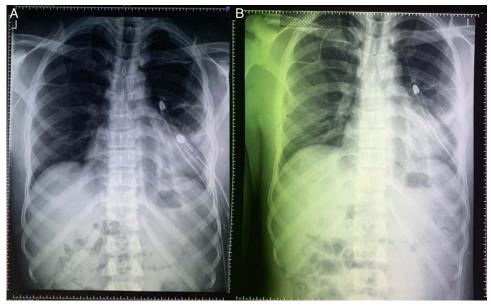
(A) shows chest radiography just after the surgery showing minimal pneumothorax; (B) shows chest radiography before discharge showing fully expanded lung with no pneumothorax.
